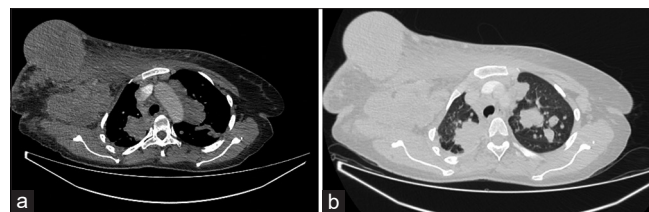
(a and b) Contrast-enhanced computed tomography scan of the upper chest in mediastinal and lung windows shows a right breast mass with an ipsilateral large nodal and lung metastasis
